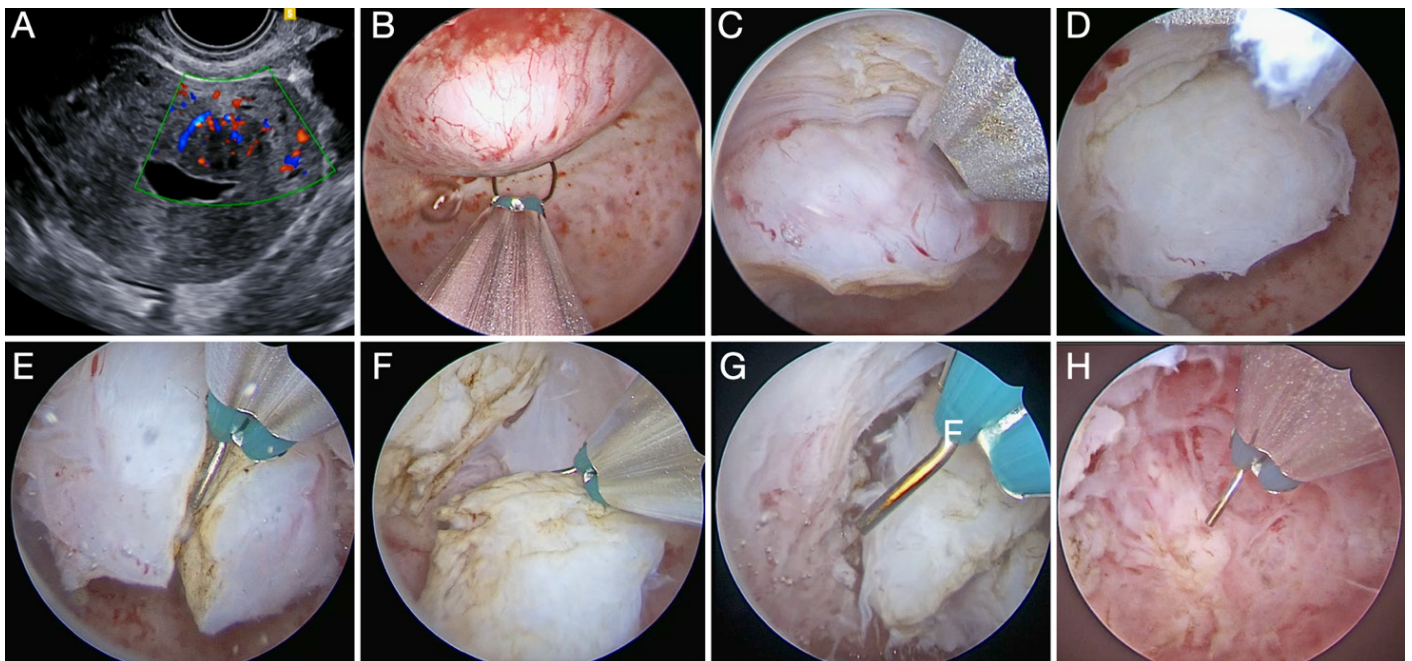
Myomectomy of a 2 cm G2 antero-fundal fibroid using a 15 Fr bipolar mini-resectoscope. A) Ultrasonographic vision of the intramural component of the fibroid. B) Removal of the intracavitary portion using the slicing technique with a 90° loop. C) Cold loop mobilization and enucleation of the intramural component using Mazzoni cold loop technique. D) Vision of the intramural portion of the fibroid exteriorized in the uterine cavity. E-G) Use of Collins loop to cut and dissect the fundal part of the fibroid from the surrounding myometrium. H) Fibroid fovea after its complete removal.
